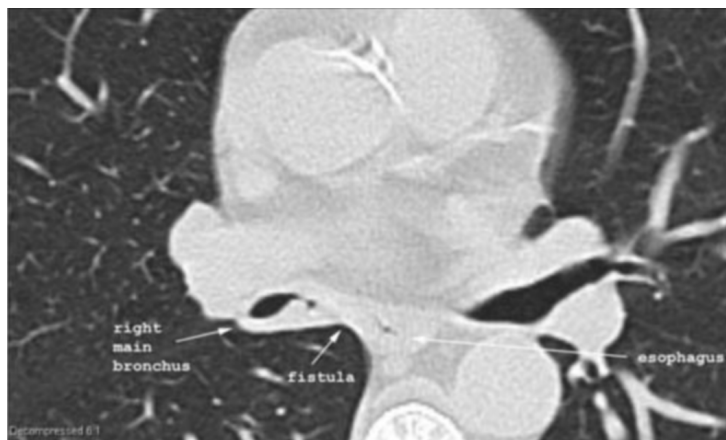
Noncontrast axial CT (lung windows) through subcarinal region shows small air collection between the right mainstem bronchus and the esophagus.
